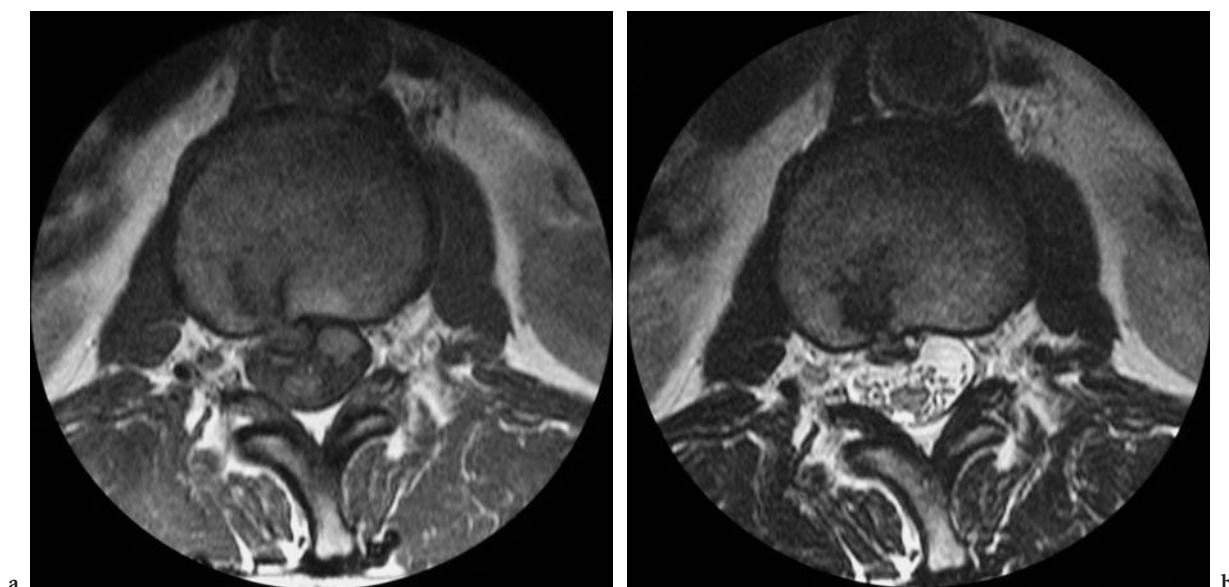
Complete radial annular tear with extruded disc at T12–L1 in a 58-year-old man. Axial T1-weighted (a) and T2-weighted (b) images. The trajectory of nuclear material through a complete radial annular tear presents a “comet tail” appearance. The extruded disc material in the spinal canal constitutes the head of the comet
